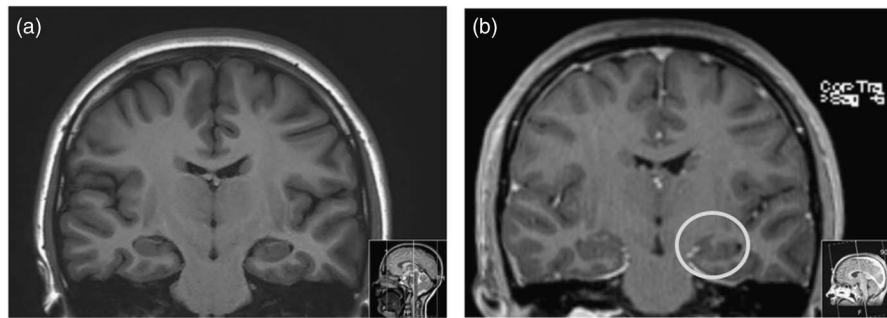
MRI scans, T1 weighted, performed on different 3 T scanners. (a) From the first episode, patient aged 16, no contrast. (b) From the second episode, patient aged 17, MRI with contrast; shows increased uptake in left hippocampus indicating inflammatory activity. Left is right in the picture.
